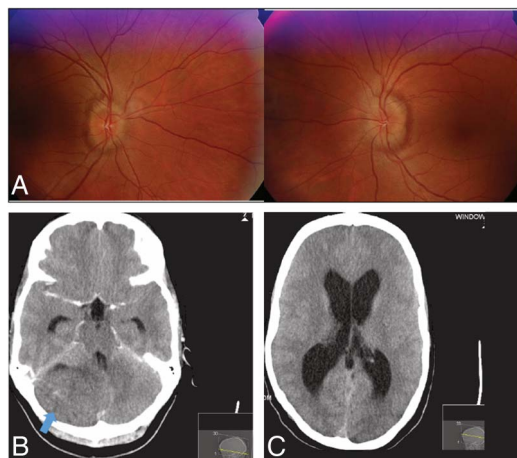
Retinography (A) of both eyes showing papilloedema (Modified Frisén Scale grade 2). Unenhanced CT (B) showing a posterior fossa tumour in the right cerebellar hemisphere (blue arrow) with isoattenuation, causing significant mass effect causing partial collapse of the fourth ventricle (arrow). Supratentorial ventriculomegaly was present (C).
